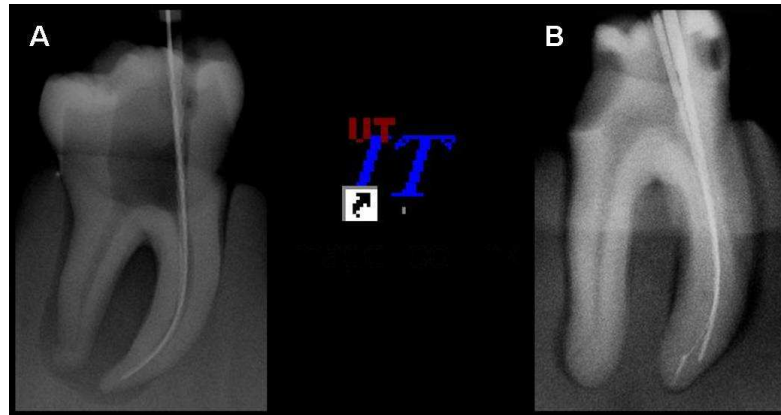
Radiografia obtida de espécime, por meio do método da plataforma radiográfica, em que não foi encontrado desvio e perda do CT (A) e em B, desvio, perda do CT fratura de instrumento.
